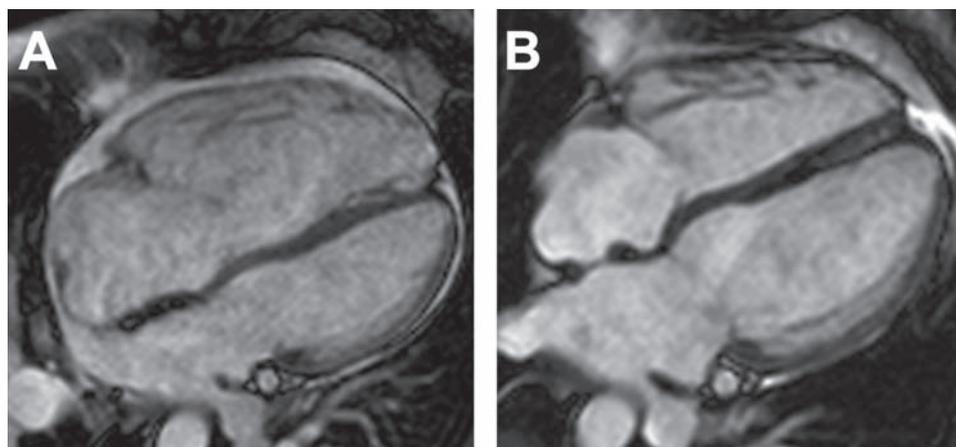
Example of imbalance. In contrast to normal balanced adaptation in healthy athletes (as seen in fig 2), cardiac magnetic resonance images of a female tri-athlete (excluded from the study) with an imbalanced relationship between right and left atrium and ventricle due to three pulmonary veins draining in the superior vena cava (partial anomalous venous return) combined with an atrium septum defect (not demonstrated here). (A) Before corrective surgery right atrium (53 mm) and ventricle (65 mm) width were much larger than the compressed left atrium (31 mm) and ventricle (46 mm). (B) Eight months after surgery the right diameters have normalised: right atrium (39 mm) versus left atrium (41 mm); right ventricle (45 mm) versus left ventricle (54 mm). For the atria, we defined maximal volume at ventricular end-systole as the slice in which the mitral/tricuspid valve is closed just before opening in the first phase, and minimal volume at ventricular end-diastole, just as the mitral/tricuspid valve closes.
